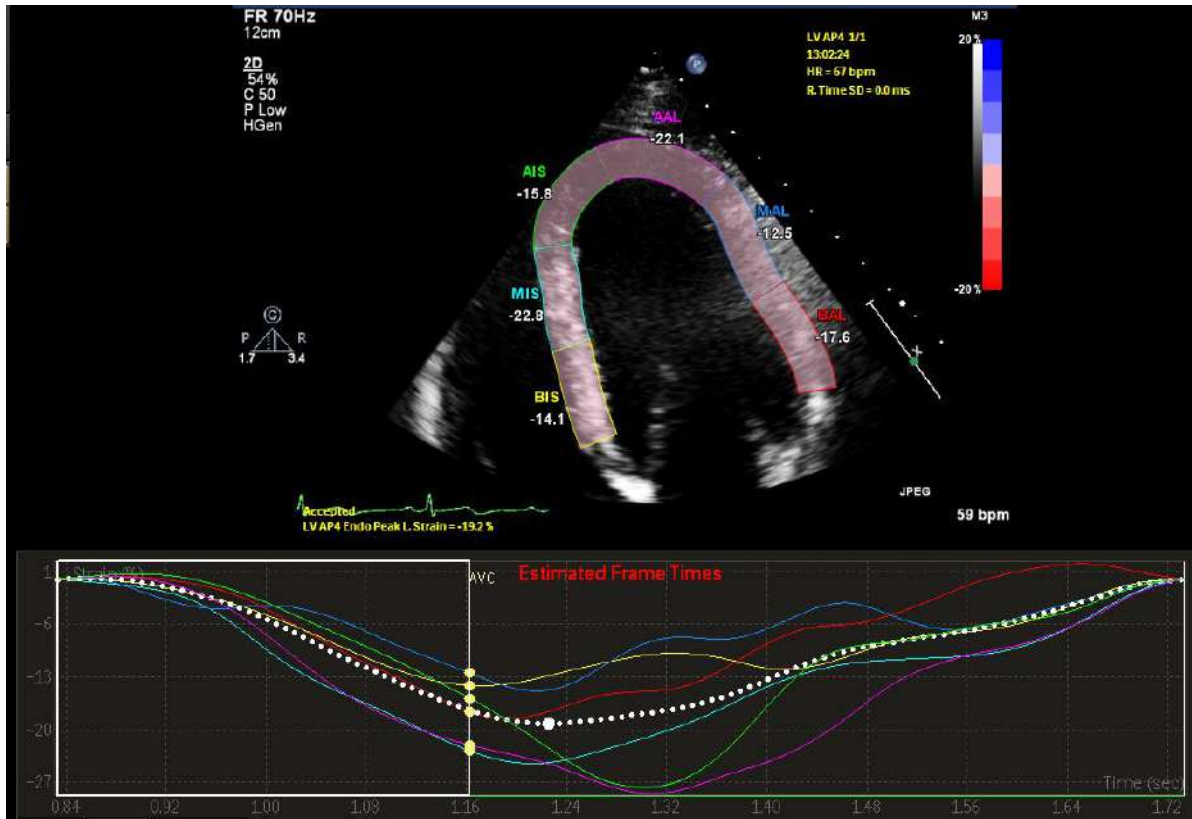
An example of strain imaging using speckle tracking in the apical 4-chamber view.
